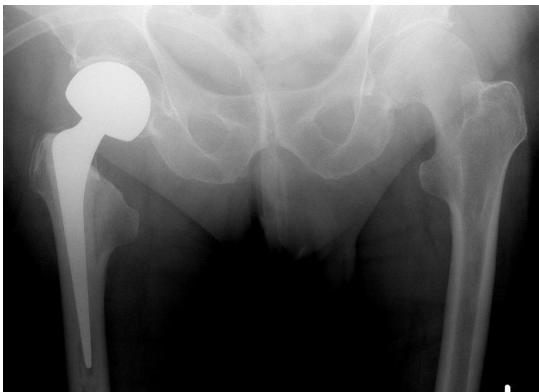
X-ray of ETS with limb lengthening. Although the neck cut has been made relatively low in relation to the lesser trochanter, the shoulder of the prosthesis slopes marginally above the greater trochanter, inadvertently lengthening the operated limb.
